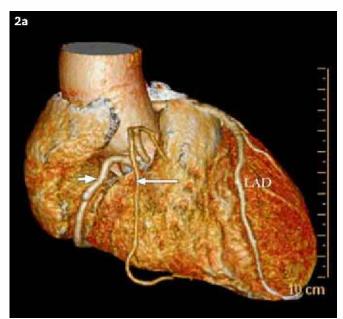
Globe MIP coronary CT angiography image of the left coronary artery (LAD) and its diagonal branches shows their course and atherosclerotic involvement. LCX: left circumflex artery
